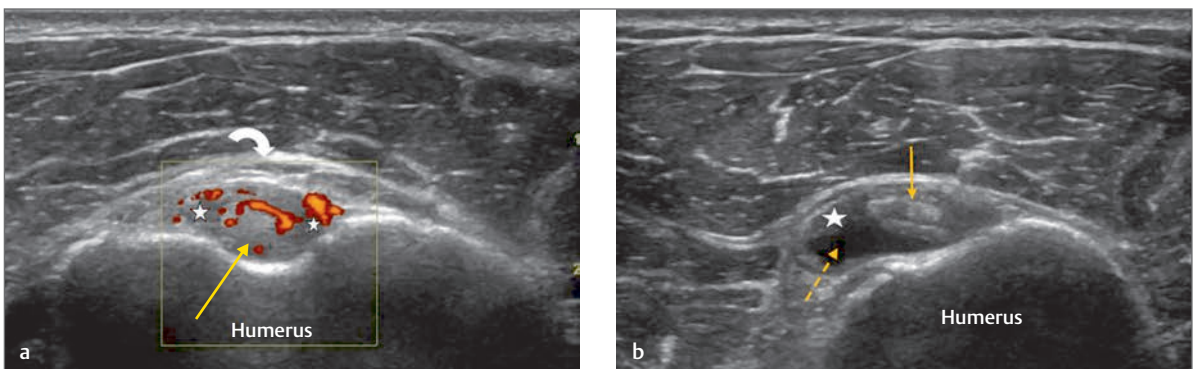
(a) Transverse images of the long head of biceps. The image above demonstrates a tendinopathic tendon (yellow arrow) at the level of the bicipital groove with bowing of the transverse ligament (white curved arrow) and synovial thickening (white stars). Doppler imaging also demonstrates an associated synovitis. (b) This image is taken distally to the bicipital groove and demonstrates fluid within the sheath (dashed yellow arrow).
